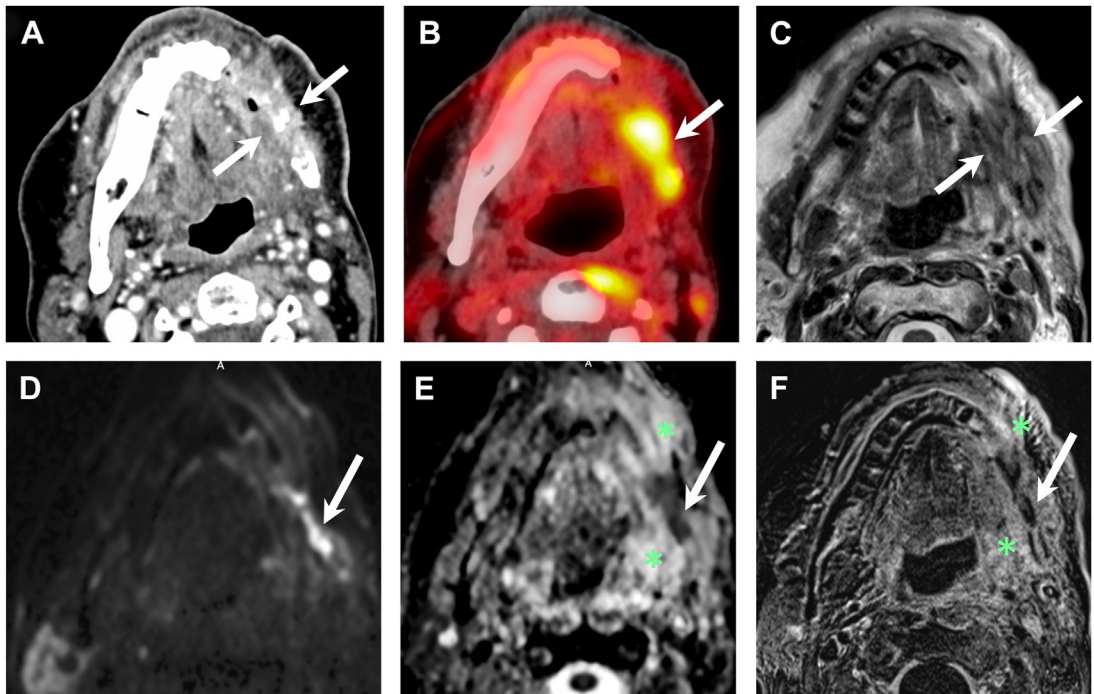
(A) Contrast-enhanced PET/CT and corresponding DWIMR imaging obtained in a 70-year-old patient with radiotherapy for SCC of the oropharynx 3 years previously. (A) Contrast-enhanced CT. (B) Fused PET and unenhanced CT image. (C) T2W image. (D) b 1000. (E) ADC map. (F) Subtraction image (T1W image was subtracted from the contrast-enhanced T1W image). On CT, an enhancing lesion (arrows) surrounding the fragmented horizontal branch of mandible is seen on the left. Strong FDG uptake (SUV_{max} , 16). On PET/CT, it is difficult to distinguish between osteoradionecrosis and recurrent SCC or a combination of both entities. There is an intermediate signal intensity on T2 within the mandible and in the soft tissues surrounding the mandible (arrows). On DWI, there is restriction of diffusivity (arrows) within the mandible but the area with restricted diffusivity does not show enhancement on F (arrow). This aspect strongly suggests osteoradionecrosis of the mandible. The soft tissues surrounding the mandible have an increased diffusivity and strong enhancement (green asterisks on E and F). They correspond to inflammation. The patient underwent hyperbaric oxygen therapy and 1 year later, there is still no evidence of recurrent SCC.
